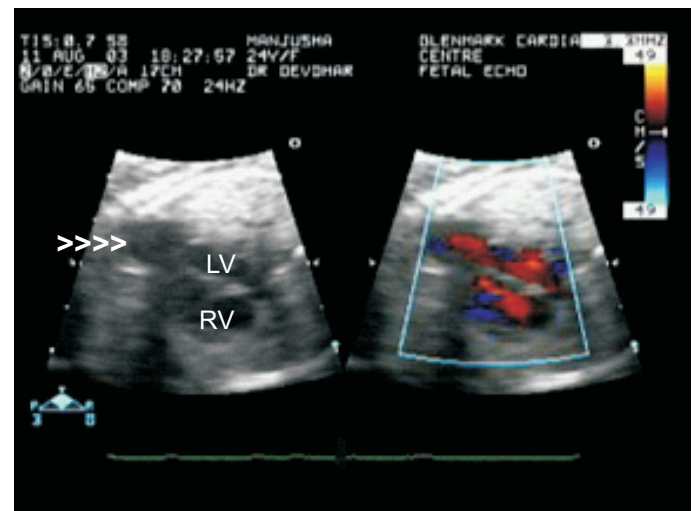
This is a case of LV diverticulum (white arrowheads). The colour Doppler shows flow from LV entering the diverticulum.
